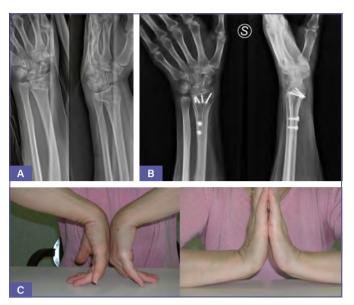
A) Pre-operative fracture pattern AO 23-A2.2 distal radius fracture in a 54 yo woman; B) 12 months post-operative X-ray in standard projection, showing fracture complete fracture healing; C) AROM evaluation at 12 months follow-up.
